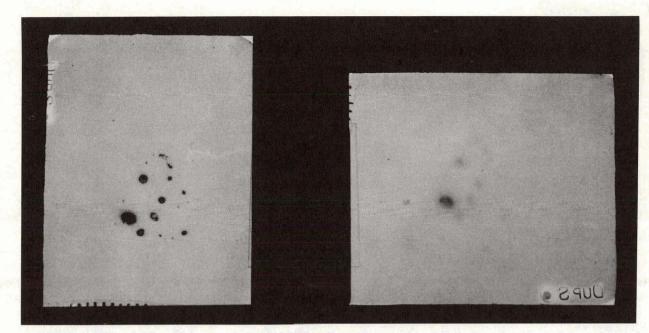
Radioautograph on dental film of I^{125} . On right a sheet of Saran wrap (10 μ thick) was interposed between the source and the film completely cutting out the low energy electrons and allowing only the x-rays to pass.
